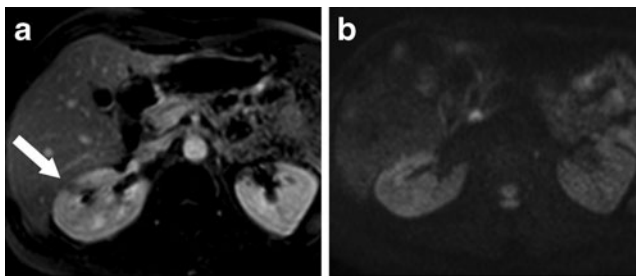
False-negative DWI study. a Small APN lesion in the middle third of the right kidney visible on T1 WAVE sequences after administration of contrast medium in the late nephrographic phase (arrow) as an heterogeneous perfusion defect. b On DWI sequences the lesion shows no signs of restriction of diffusivity.
